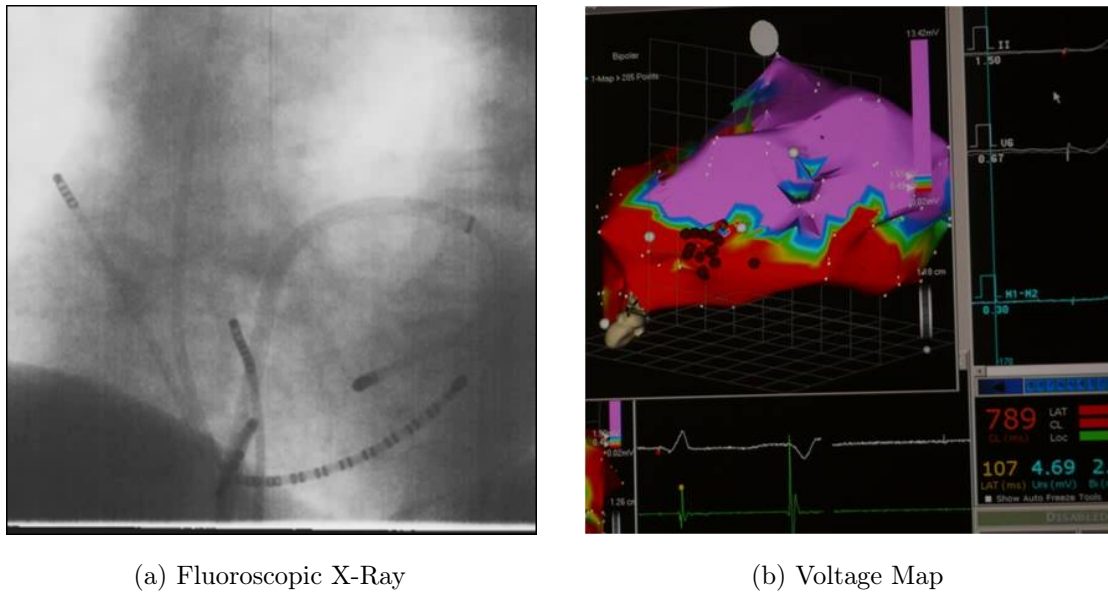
Fluoroscopic x-ray image of catheters ablating the heart and an endocardial voltage map visualizing voltages across the ventricle using a color-map.
